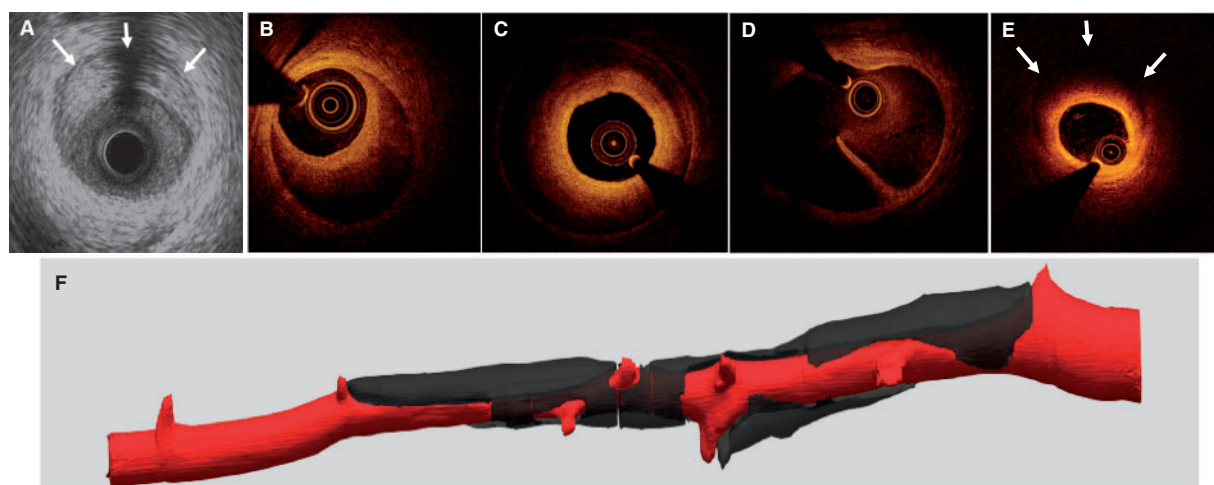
Intracoronary imaging of spontaneous coronary artery dissection by intravascular ultrasound (with outer border of false lumen arrowed, A), and optical coherence tomography showing partial (B) and circumferential (C) false lumens; the site of a fenestration (D) connecting true and false lumens and reduced light penetration through the false lumen (E). Three-dimensional image derived from segmentation of optical coherence tomography image showing how the false lumen tracks around the true lumen and is influenced (and frequently bounded) by side branches (F).
